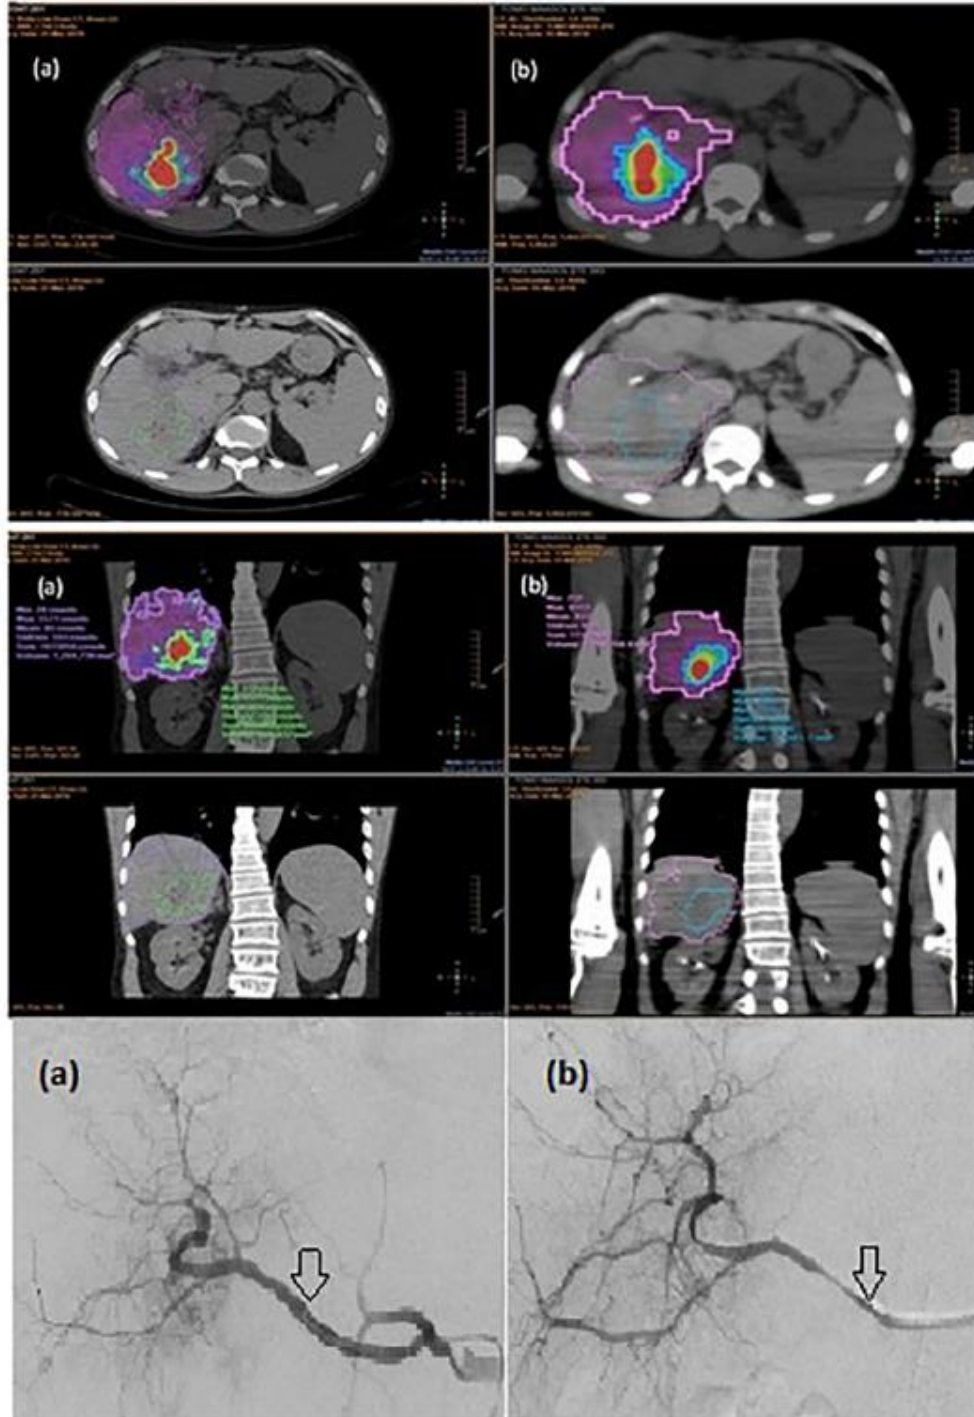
The left side shows the pre-treatment imaging (SPECT/CT); The right side represents the post-treatment imaging (PET/CT) [17].
